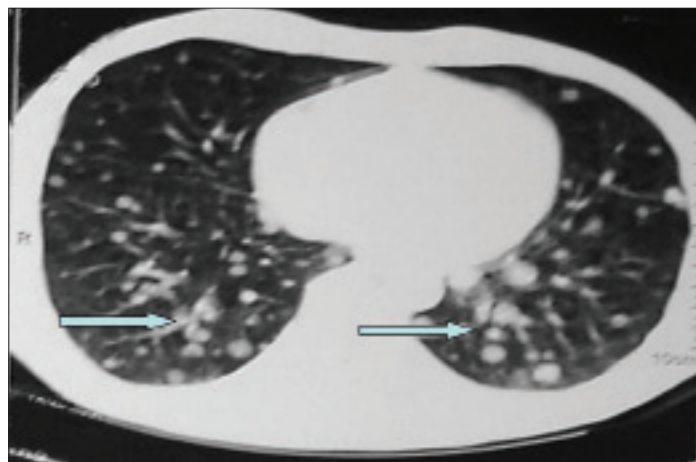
Computed tomography scan thorax confirming multiple nodular opacities in both lungs
